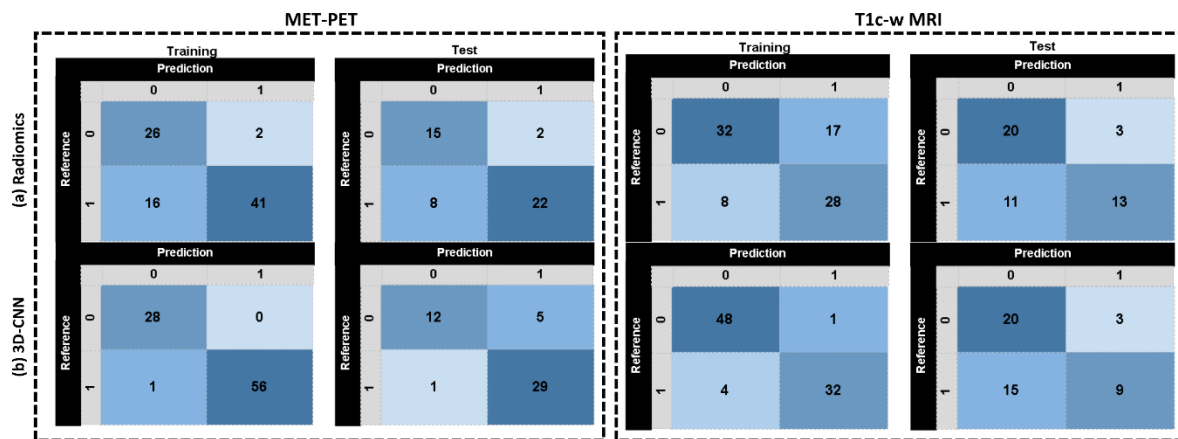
Confusion matrices for residual status prediction in training and test data based on MET-PET and T1c-w MRI data (a) using the final radiomics-based logistic regression model and (b) using the final 3D-DenseNet model.
